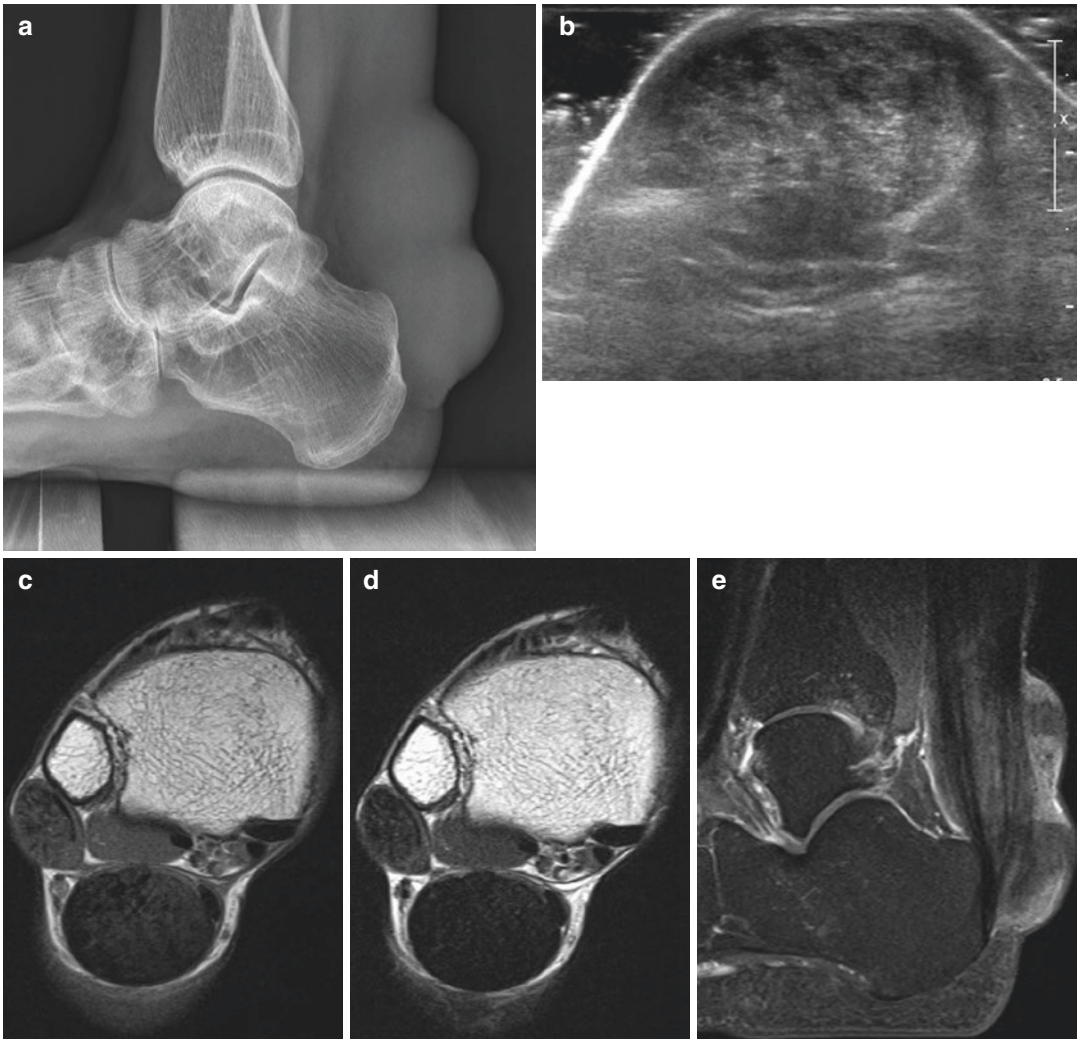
Xanthoma. Lateral radiograph of the ankle (a) shows a lobulated bulging soft tissue contour in the posterior aspect of the ankle. Transverse US (b) demonstrates marked diffuse thickening of the Achilles tendon, with a diffuse heterogeneity. Confluent hypoechoic areas and thin hyperechoic foci are observed within the tendon, causing a loss of the fibrillary pattern of tendon. MR
